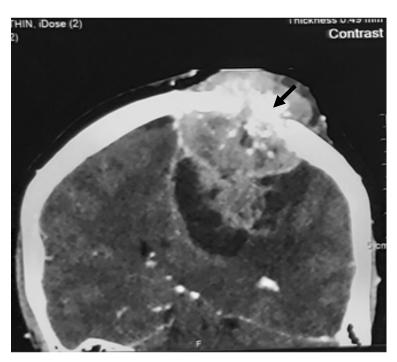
Contrast enhanced CT scan of brain in reformatted coronal plane showing large heterogeneously enhancing extra-axial mass along left parietal convexity causing partial destruction of left parietal bone (arrow), invasion of underlying leptomeninges, left parietal lobe and mid line shift towards contralateral side
